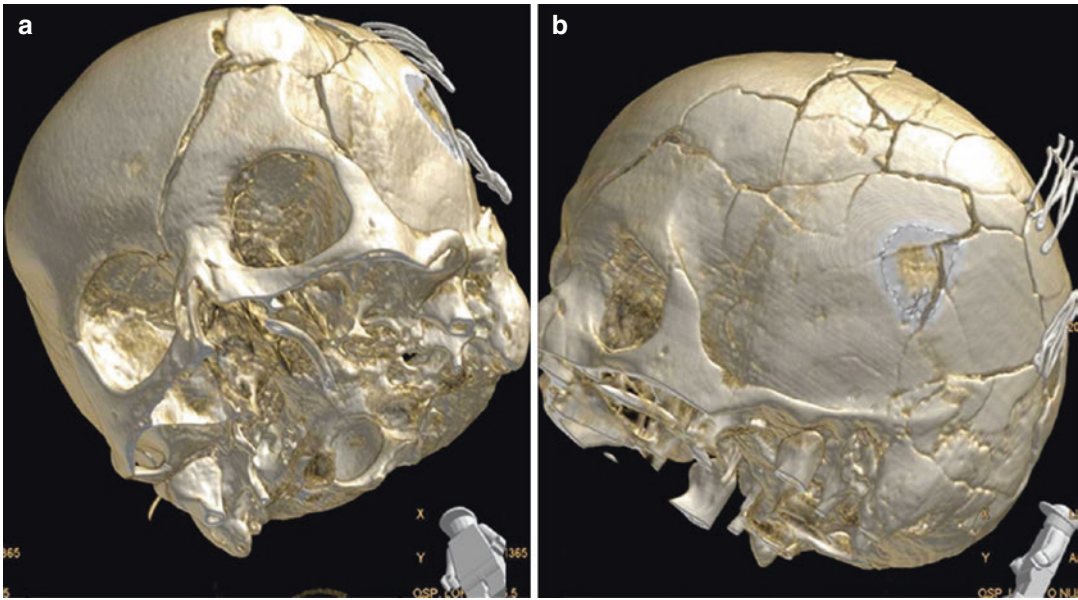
(a, b) Three-dimensional CT reconstructions. Comminute cranial vault fracture, well delineated on 3D reconstructions
